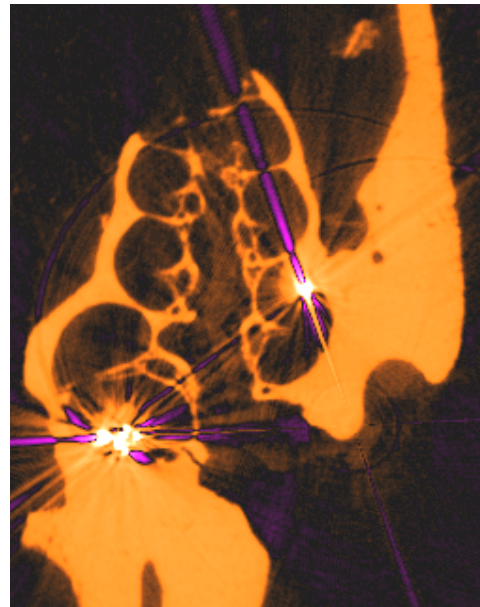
μ -CT cochlear slice with colour map applied to enhance contrast between cochlear structures.
